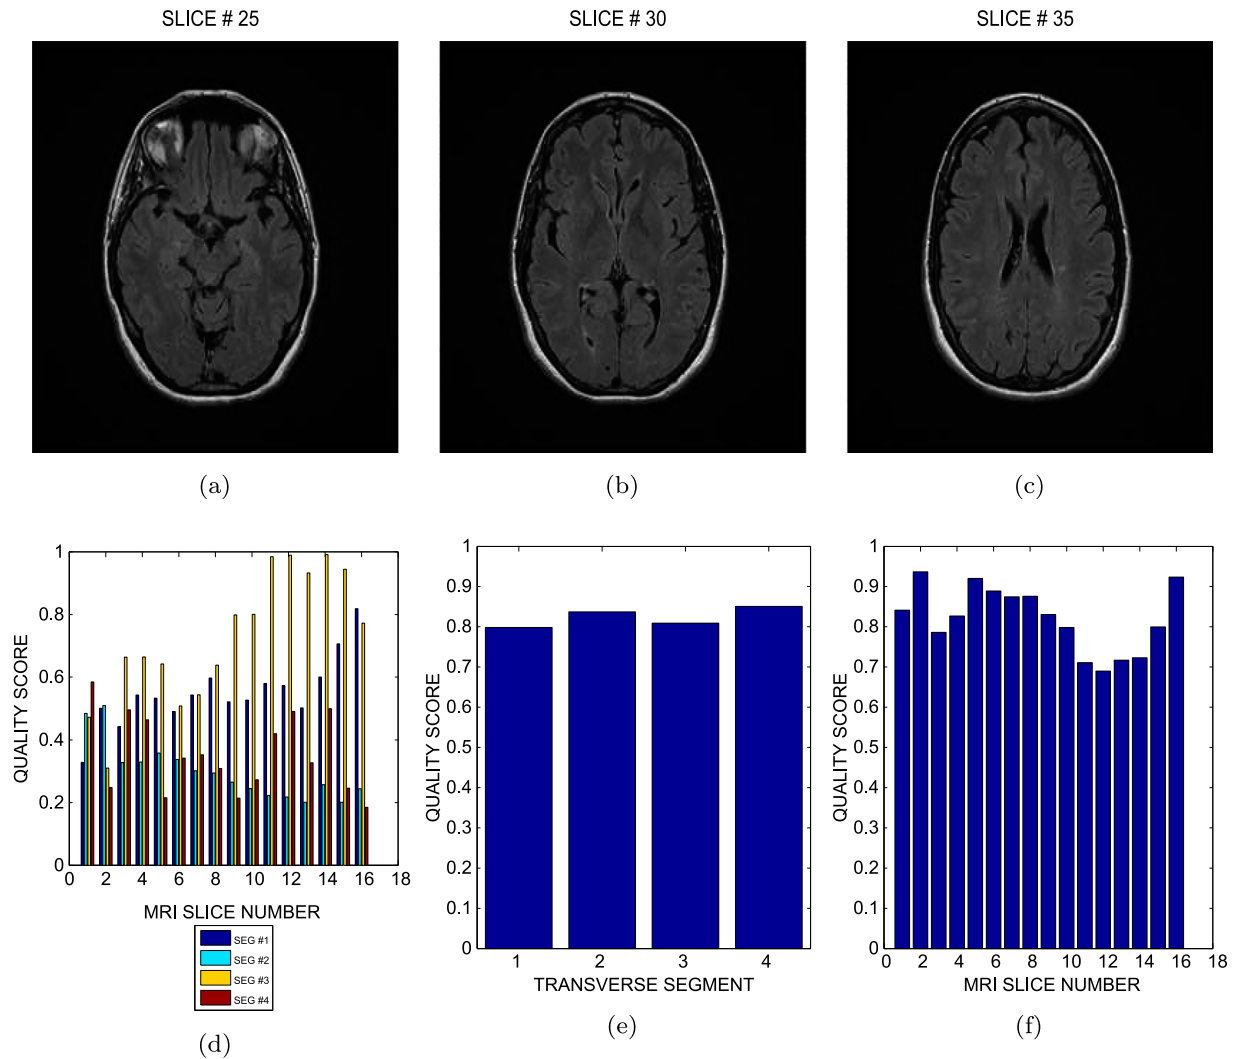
(a), (b), (c) Three FLAIR slices in the MRI volume data from NeuroRx. d) Whole brain angular segment pixel density (e) Transverse segment pixel density (f) Whole brain pixel density, quality scores for sixteen successive slices in the volume data.
